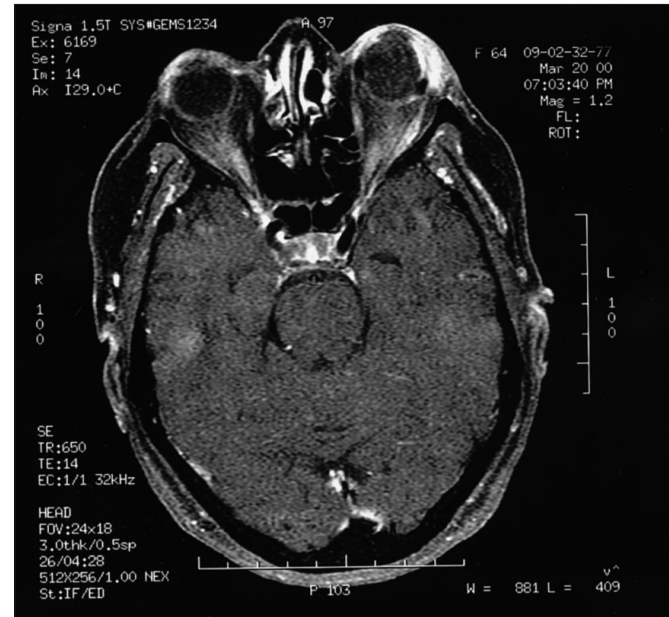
T1-weighted image (repetition time/echo time=650/14; FOU 24x18) with gadolinium contrast and fat suppression shows hypointense silicone explant and increased signal intensity of the preseptal region in the left eye (Case 12).
